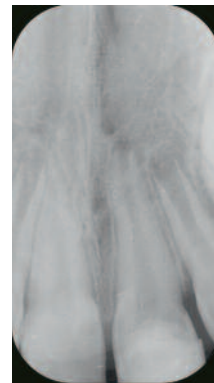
/1N: Recall radiograph at 6 and 12 months, showing continued root formation
